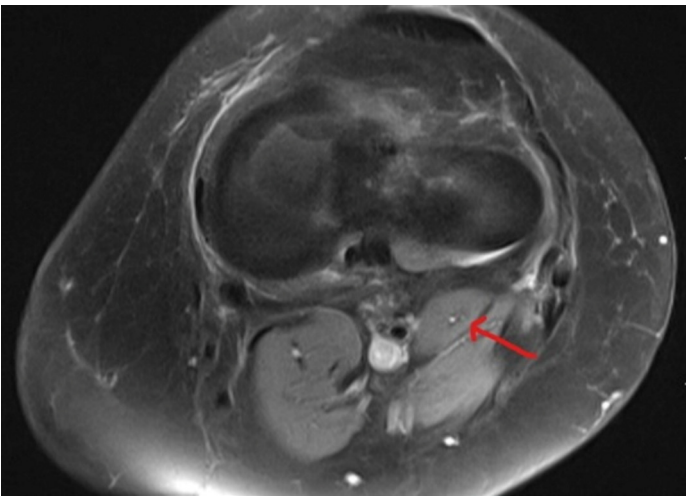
Axial MRI plantar muscle
